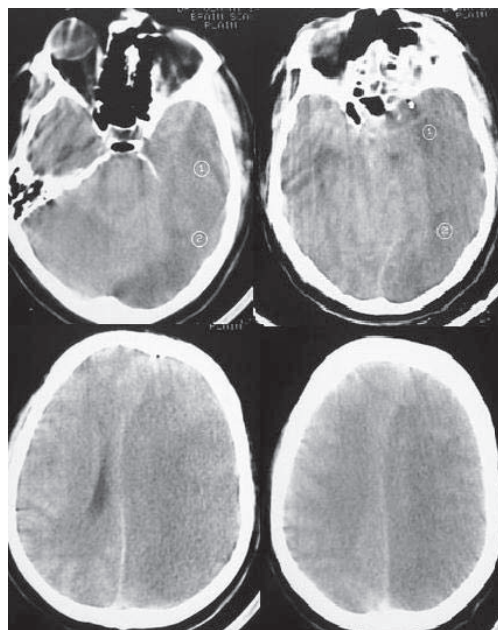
Axial CT showing extensive hypo density involving the grey white matter of the left fronto parietal and temporo occipital region including the ipsilateral basal ganglia.interhemispheric subdural bleed, brain swelling, midline shift and uncal herniation is also seen.
